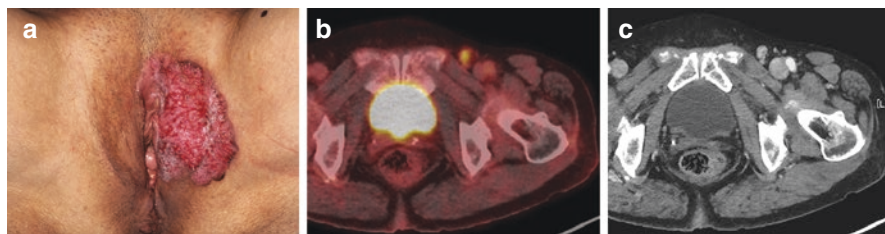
EMPD case with a false-positive result on ^{18}F -FDG PET-CT. A 66-year-old woman developed erythema in her genital area (vulva) and was pathologically diagnosed with extramammary Paget disease (a). An asymmetrically enlarged regional lymph node in the left groin (SUV_{max} , 6.45; SUV_{peak} , 2.77) was identified on ^{18}F -FDG PET-CT, which suggested lymph node metastasis (b, c). However, metastasis was not detected in the excised lymph node
